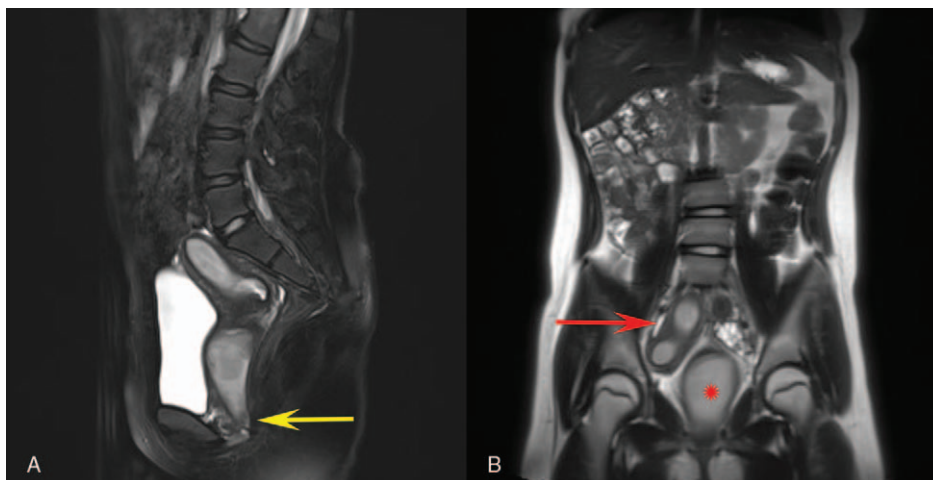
Magnetic resonance imaging scan showing (A) distal vaginal atresia (yellow arrow) and (B) a dilated upper vagina due to hematocolpos (red asterisk) with a bicornuate uterus with 2 horns (red arrow).
